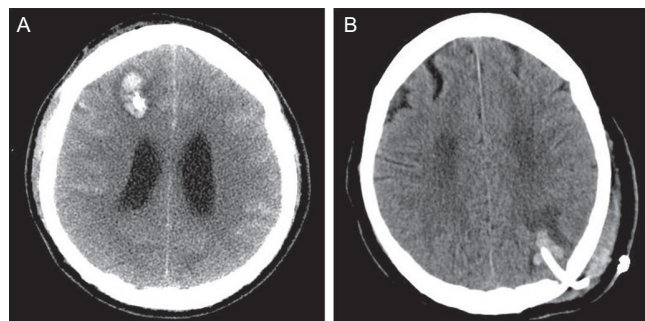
Grade 2 hemorrhages after external ventricle drainage (A) and ventriculoperitoneal shunt (B) procedures. Maximum diameters of catheter-associated hematomas were less than 3 cm on computed tomography scans.
